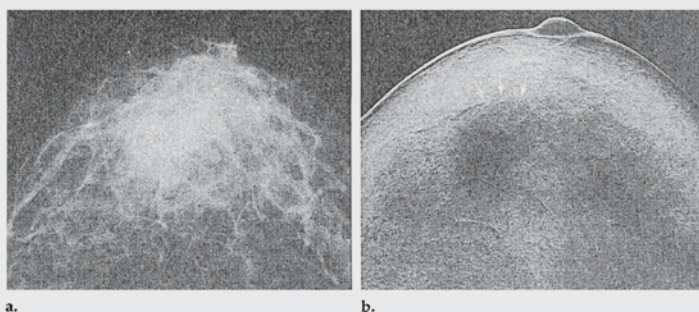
Scirrhous carcinoma. (a) Craniocaudal low-energy image. (b) The border of cancer infiltration (arrows) was revealed by dual-energy subtraction radiograph.
